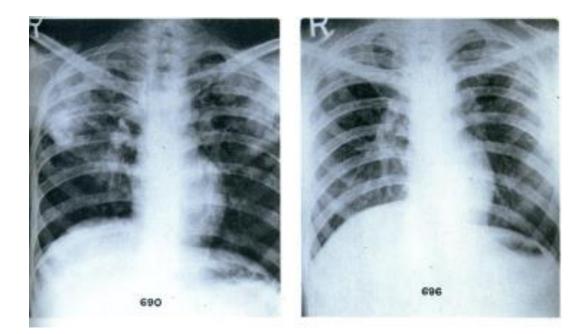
Chest X-ray pre and post treatment with Streptomycin ⁽²⁾
